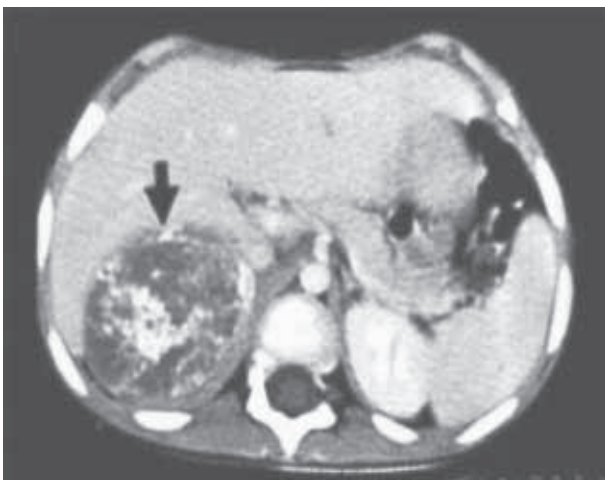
Retroperitoneal neuroblastoma (CT)
